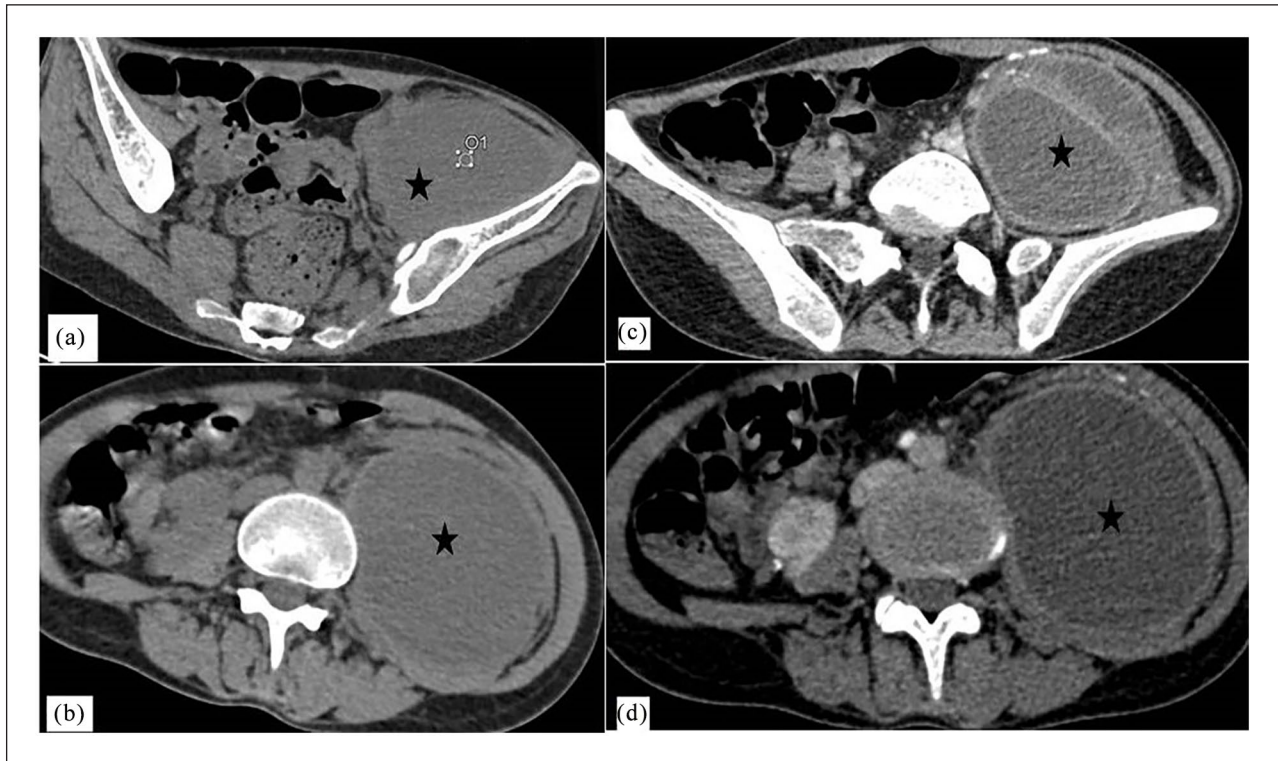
Axial view of abdominal and pelvic computed tomography-scan before (a) and (b) and after (c) and (d) contrast injection showing a large left psoas muscle abscess (black stars).
